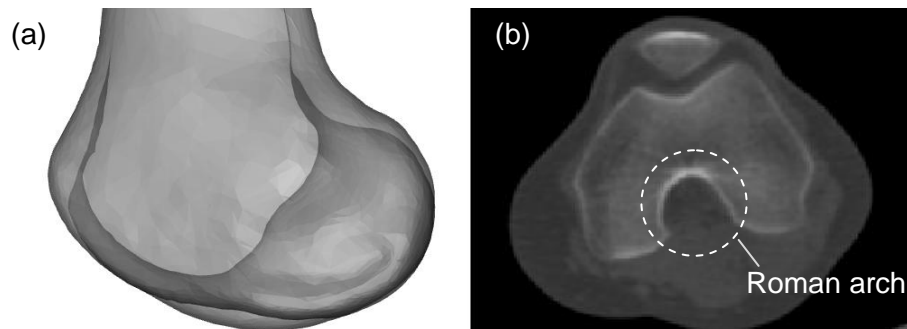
(a) Lateral view of the distal femur, (b) First transverse CT slice on which the roman arch is visible when examined from the distal side.
